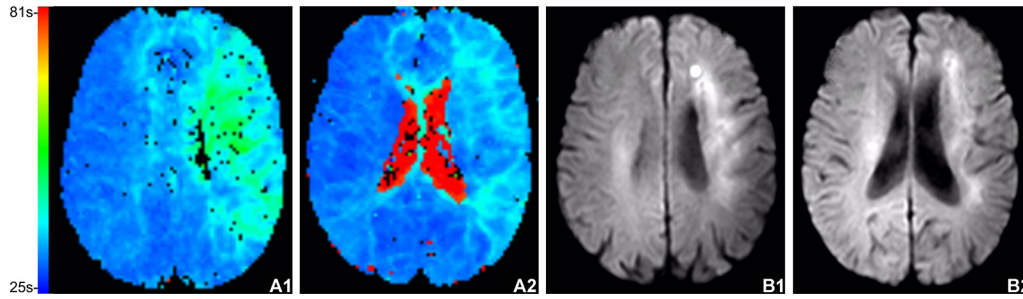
MRI including DWI and PWI was performed 1 week before and 6 weeks after CEA to evaluate cerebral perfusion. Changes in PWI pre- (A1) and post-CEA (A2) and in DWI pre- (B1) and post- (B2) CEA are shown. CEA = carotid endarterectomy; MRI = magnetic resonance imaging; PWI = perfusion weighted imaging; DWI = diffusion weighted imaging.
